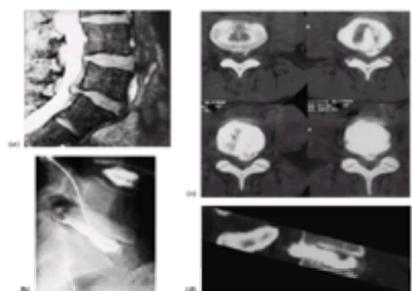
Disc prolapse. (a) MR scan, T_2 -weighted image. There is dorsal protrusion of a disc impinging upon the theca and narrowing the sagittal diameter of the canal. (b) The discogram demonstrates this lesion, showing a posterior annular tear with partial opacification of the bulge. A normal disc is demonstrated at the L4/5 level. (c) CT scanning following this study shows the degenerate disc with the central and left-sided protrusion. Sagittal reconstructions are also obtained (d).
